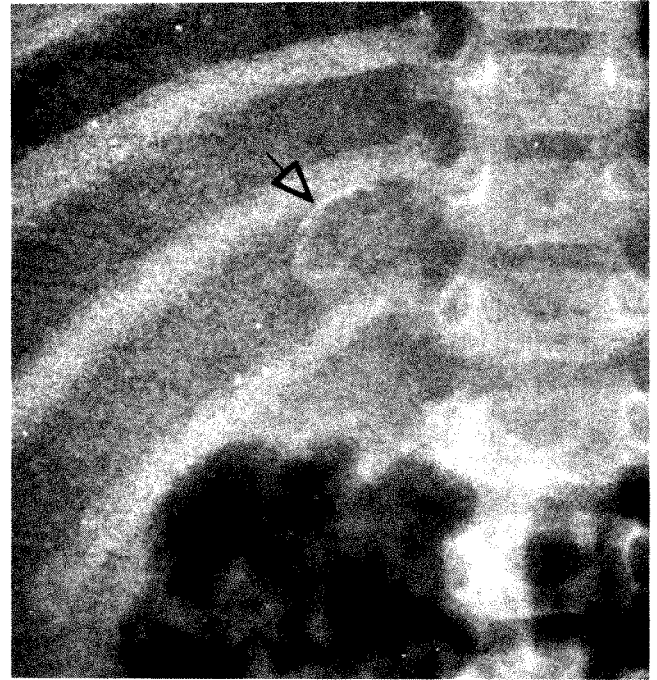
Plain radiograph of right upper quadrant at 8 months of age showing rimlike adrenal calcification (arrow) which has become smaller and denser.
